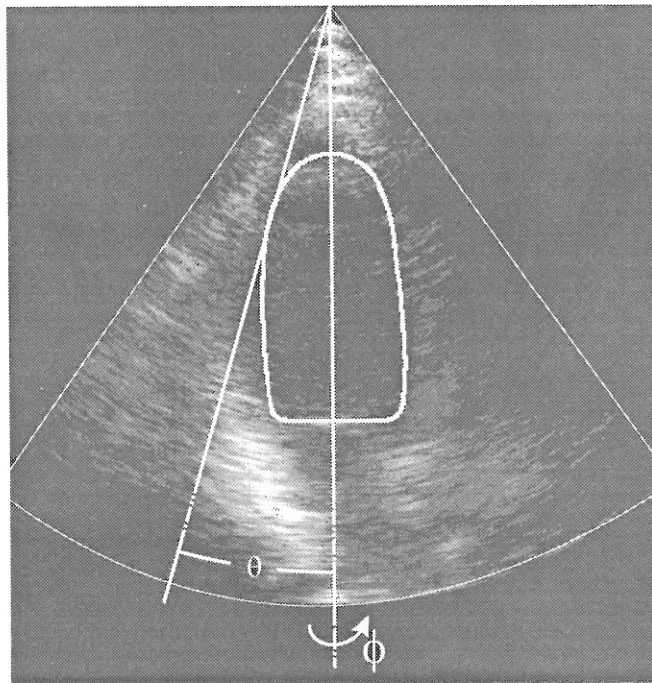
Example of an ultrasound image recorded during the probe rotation. θ is the beam angle. ϕ is the rotation angle.
